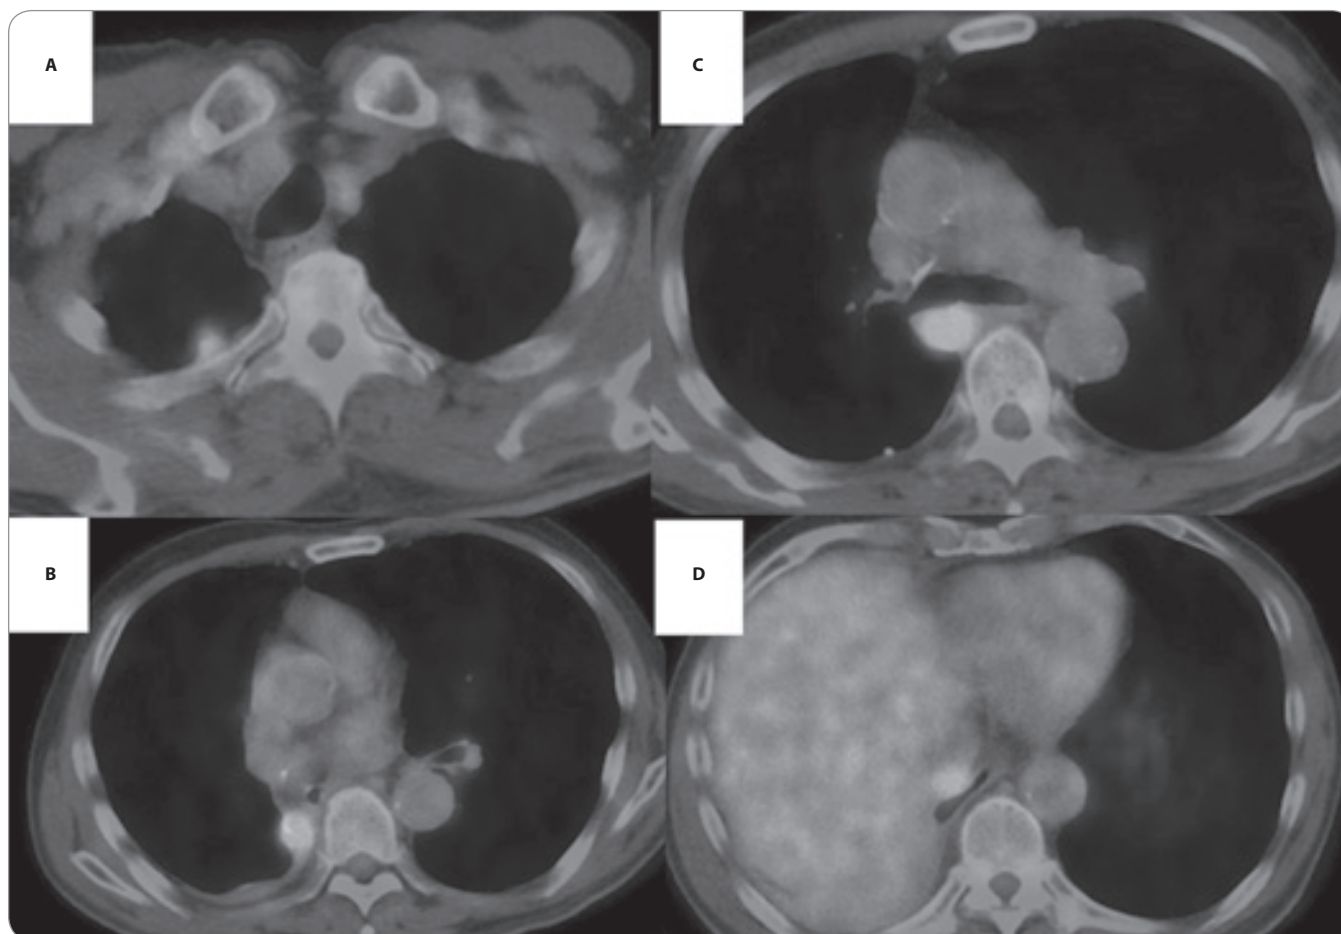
PET/CT scan 6 months after surgery revealed pleural dissemination (A, B) and recurrence in mediastinal lymph nodes (C, D).
